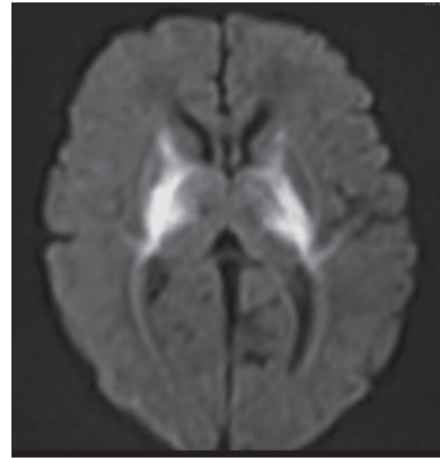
Axial DWI shows restricted diffusion in posterior limb of internal capsule
